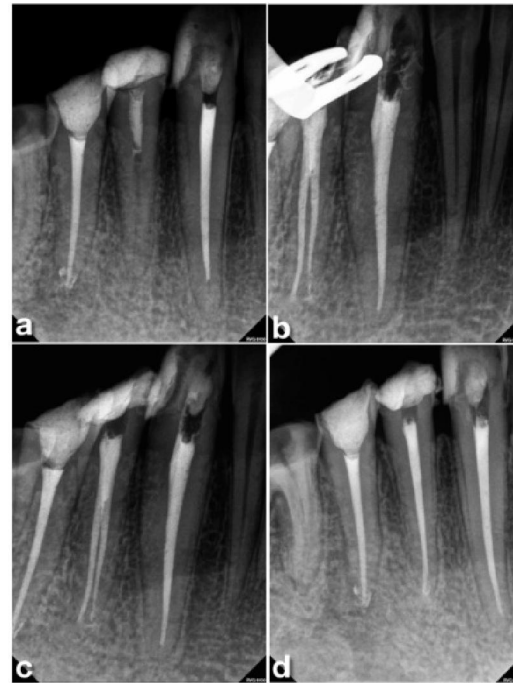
Case 2: a, preoperative radiograph . b, post obturation radiograph. c,d Postoperative radiograph (straight and mesial shift).
